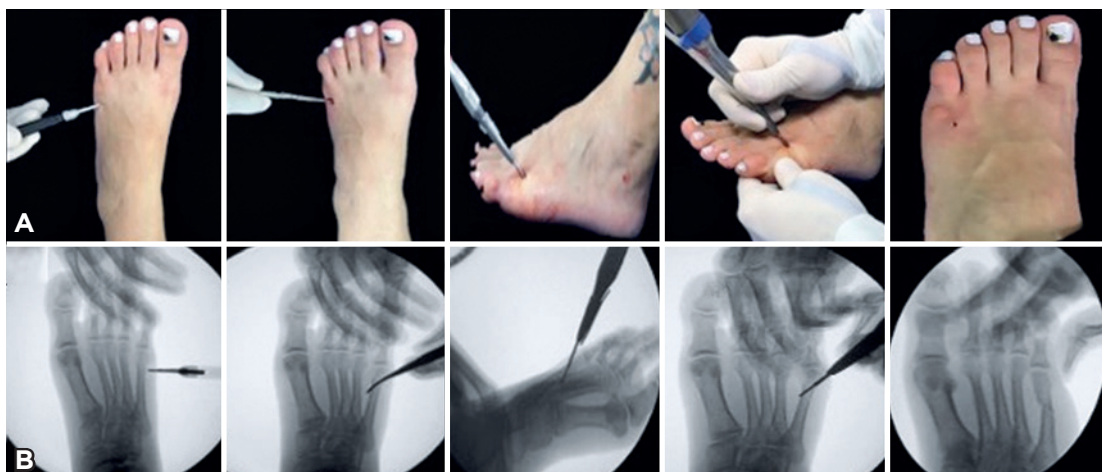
Intraoperative sequence of the surgical technique; A) Clinical image; B) Radiographic image.
